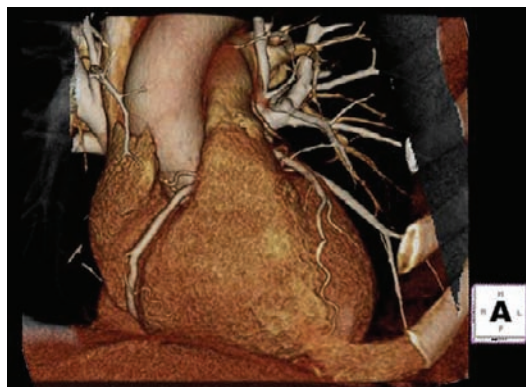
Volume-rendered computed tomography reconstruction image demonstrating epicardial coronary and great vessels in relation to the bony thorax.
